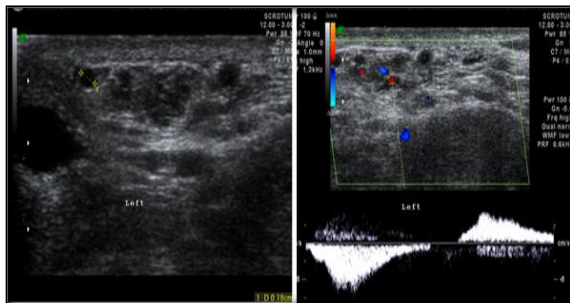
Infertile male patient of 30 years with unilateral varicocele; Gray scale image showing undilated venous plexus (0.18) cm, with mild reflux lasting for 2 secs on left side on doppler study.
